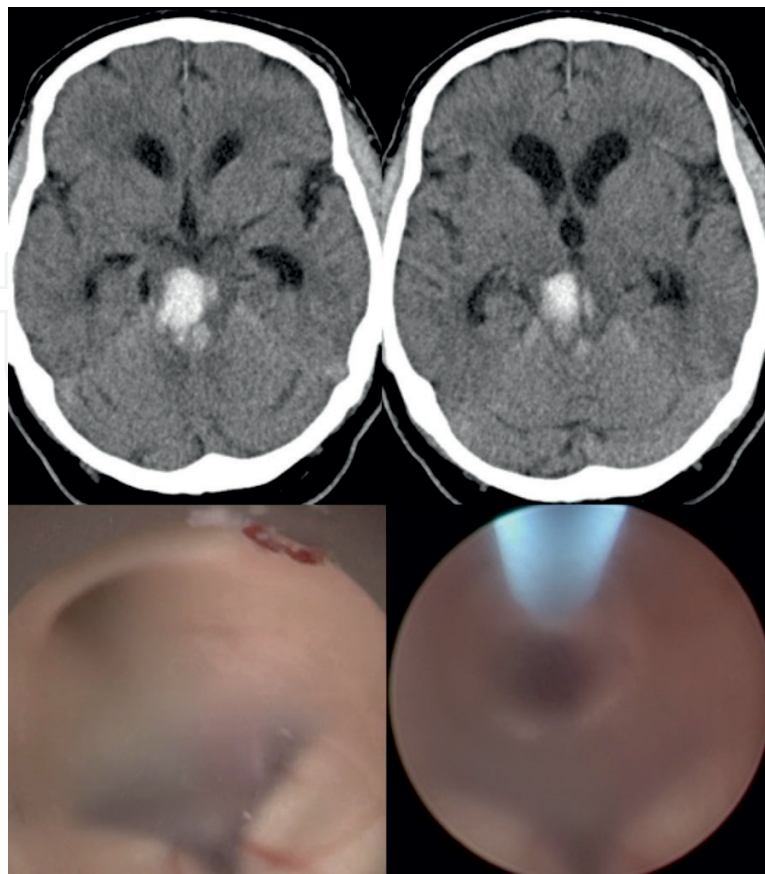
Intraventricular hemorrhage of fourth ventricle with occlusive hydrocephalus. Obscured view due to the bleeding (above) and preoperative CT scan (left below) landmarks of third ventricle—infundibular recess, mammillary bodies (right below), balloon dilatation.
